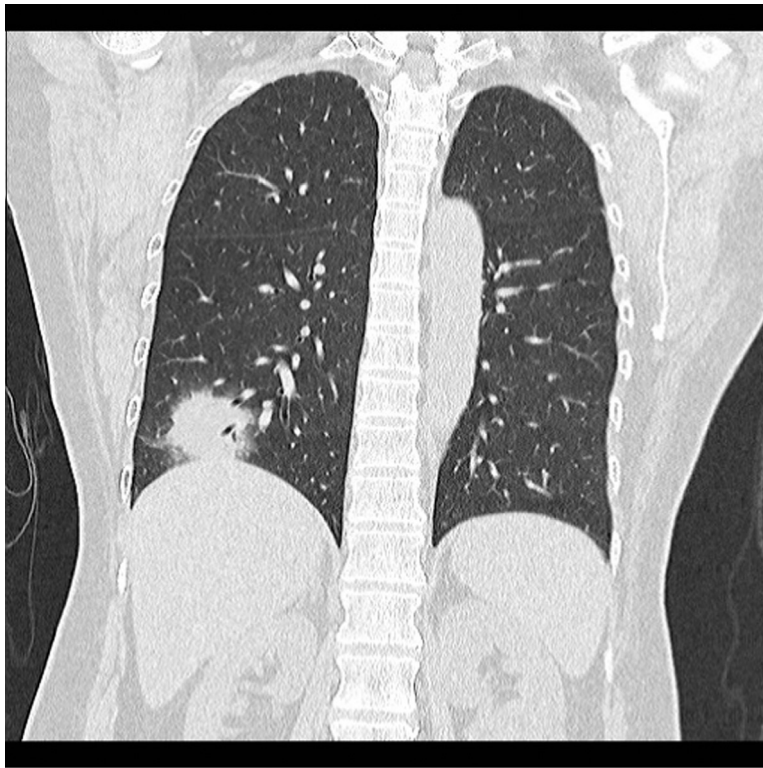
Coronal CT of the chest in pulmonary window at presentation showing the opacity much distinct in the right lower lobe.
